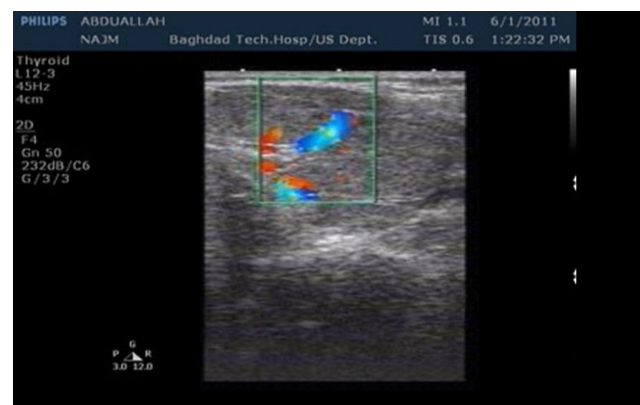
Showing central vascularity in a thyroid nodule on Color Doppler
